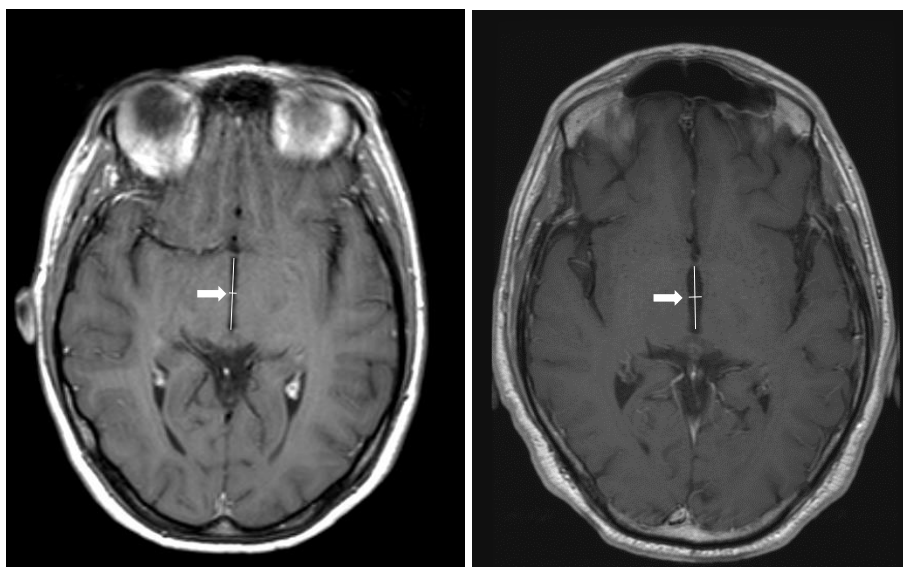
Third Ventricle Width (TVW) was measured as the width of the third ventricle at the midpoint (see white arrow) of a line running parallel to the long-axis of the ventricle on axial T₁- weighted MRI scans.
